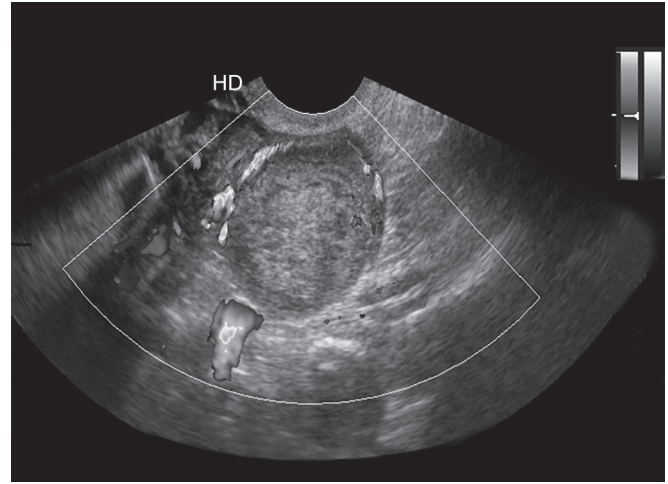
Transvaginal scan color Doppler of right adnexa showing trophoblastic activity at the periphery of the ectopic mass
